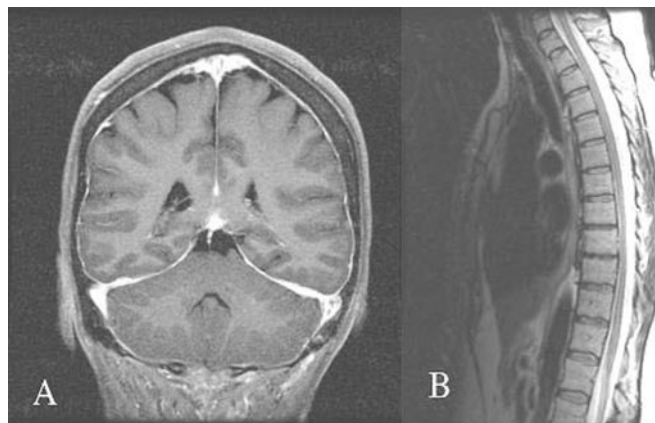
(A) Gadolinium-enhanced coronal T1-weighted image showing diffuse, symmetric, linear, contiguous pachymeningeal enhancement involving the dura mater of the convexities, tentorium, and falx without leptomeningeal involvement (no extension into sulci). (B) Post-gadolinium T1-weighted sagittal image showing diffuse enhancement surrounding the spinal cord.
